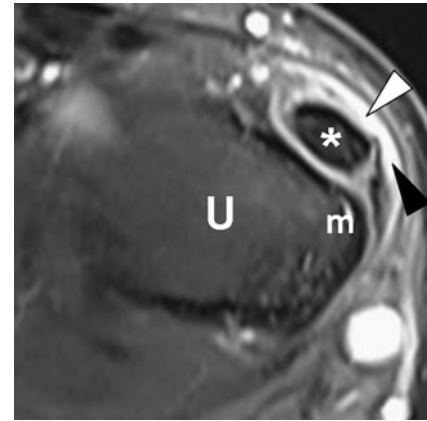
Transverse Gd-enhanced FS T1-weighted spin-echo MR image (501/15) with wrist pronation in a 22-year-old male patient with a type A injury of the ECU subsheath (white arrowhead). The subsheath is torn near its medial attachment site (m) and a contrast-enhanced associated pouch (black arrowhead) is noted (U ulna, * ECU tendon)
